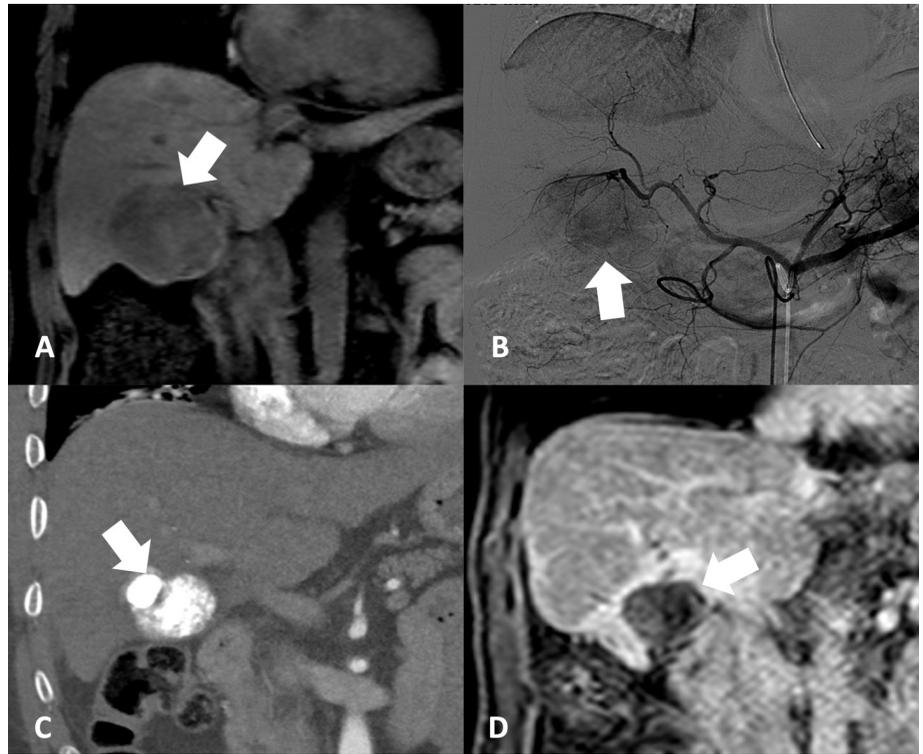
A 54-year-old man with cirrhosis secondary to alcohol use. (A) Coronal image from a T1-weighted magnetic resonance imaging (MRI) scan without contrast demonstrates a 6.2 cm hepatocellular carcinoma (HCC) in the inferior right hepatic lobe (white arrow). (B) Digital subtraction angiogram from the celiac artery during conventional transarterial chemoembolization (cTACE) demonstrates tumor hypervascularity (white arrow), consistent with preprocedural imaging. (C) Coronal reformatted image from a contrast-enhanced computed tomography scan in arterial phase shows excellent coverage of the tumor with radiopaque ethiodol (white arrow). (D) Coronal slice from a T1-weighted, contrast-enhanced MRI scan in portal venous phase obtained approximately 1 year after cTACE followed by stereotactic body radiation therapy (SBRT) demonstrates no residual enhancement in the tumor (white arrow), consistent with a complete tumor response. The patient began SBRT approximately 3 months after cTACE. The patient received a total dose of 45 Gy in 3 fractions over 8 days.
